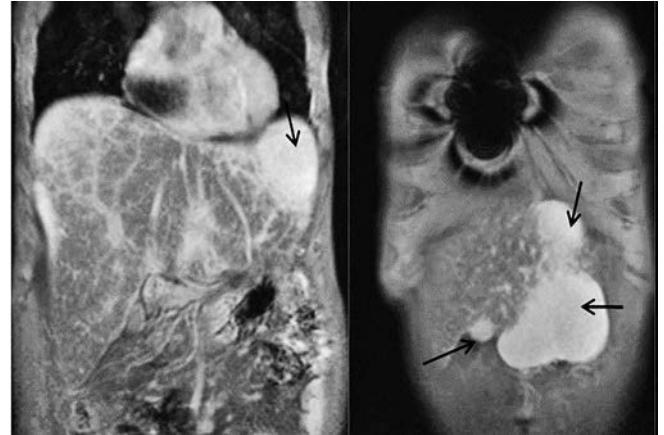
Post contrast MRI of the liver (delayed phase): heterogeneous enhancement of the parenchyma with nodular lesions showing increased enhancement as compared to the rest of the liver (black arrows).
